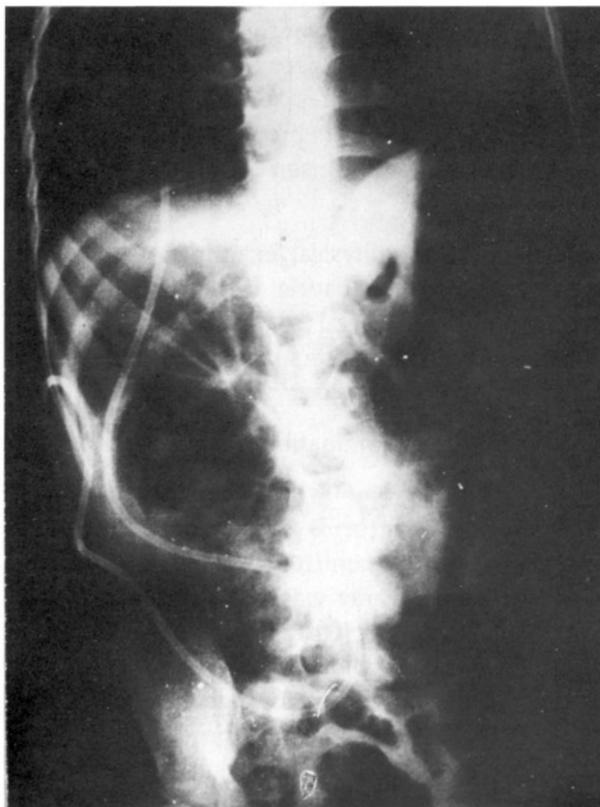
Direct X-ray of peritoneal catheter. The tip of the catheter is seen at the right flank.
